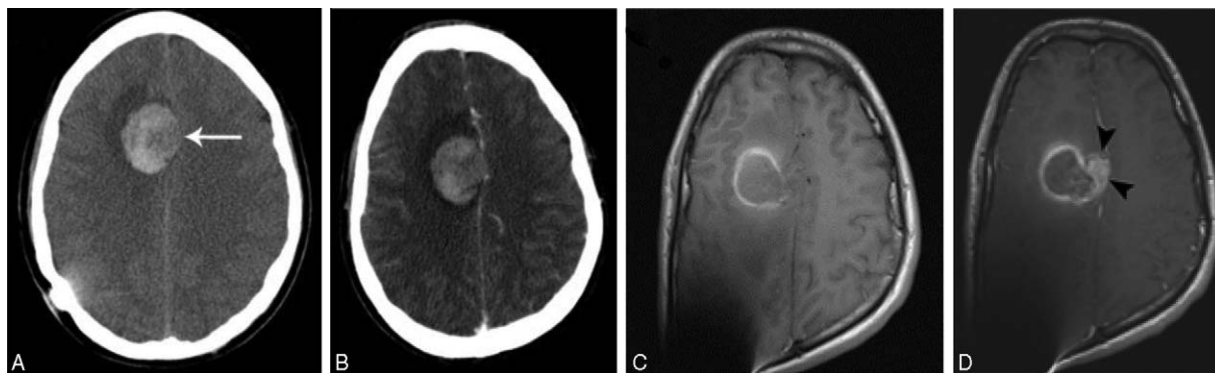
CT and MRI images of patient with right cochlear implant and new onset of seizure. A, Axial pre-contrast CT shows a hyperdense hemorrhagic paramidline lesion (*white arrow*). B, Post-contrast CT is essentially noncontributory as areas of enhancement cannot be distinguished from high density blood products. C, Pre-contrast T1-weighted fast spin echo MR images show some high signal associated with blood products. Note the susceptibility artifact posteriorly from a right implant. D, Post-contrast T1-weighted fast spin echo MR images demonstrate an enhancing mass along medial margin (*black arrowheads*). Biopsy revealed a malignant melanocytic lesion.
